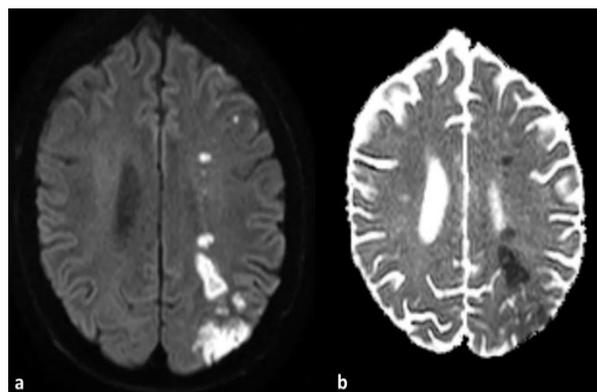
Deep and cortical acute watershed infarction. Brain magnetic resonance imaging (MRI) in a middle-aged man with coronavirus disease 2019 (COVID-19) shows a unilateral watershed territory infarct in the left middle cerebral/posterior cerebral arteries and the deep watershed territories as evident in the axial diffusion-weighted image (DWI) (a) and apparent diffusion coefficient (ADC) map (b).
